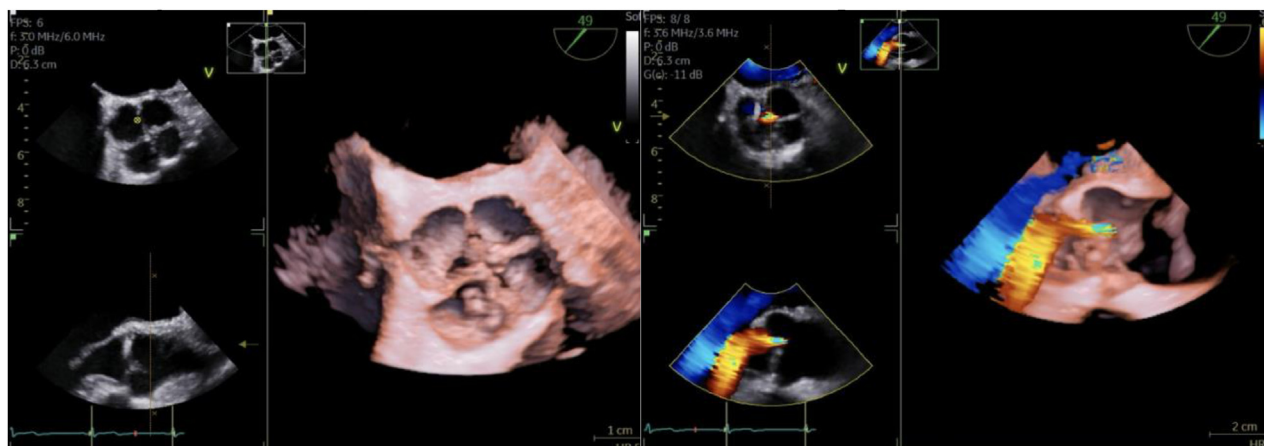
Case 3. Three-dimensional TEE, midesophageal simultaneous biplane short- and long-axis diastolic views with volume-rendered reconstruction en face diastolic display of the AV from the perspective of the aorta without (*left*) and with (*right*) color flow Doppler, demonstrates four distinct cusps characteristic of QAV with mild leaflet thickening and mild AR.
